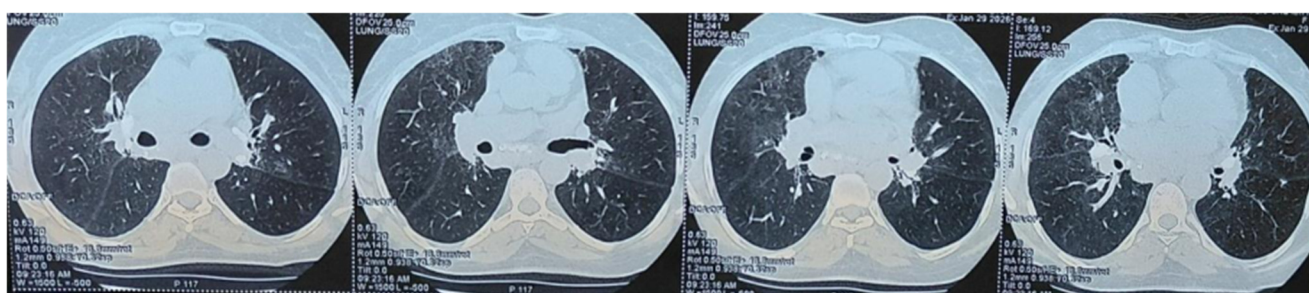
Chest computed tomography, axial slices in parenchymal window, showing fibrosing interstitial lung disease.
